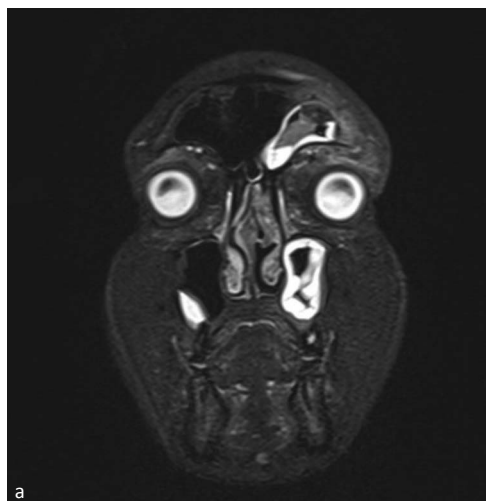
MRI with contrast: In comparison to the previous CT examination, there was smaller edema of the left maxillary mucosa, there was present residual abscess in the superior part of the left orbit 10 x 3 x 4 mm. The edema of the soft tissues around the abscess was found. There are signs of the edema and enhancement of the bone marrow of the left frontal bone, laterally to the frontal sinus – the suspicion of the bony inflammation. The enhancement of the dura above the frontal lobe was also found – with the dural thickening in this area at the length of 10 mm at the level of the inflammation in the frontal sinus. The most concerning finding was a linear loss of contrast in the posterior part of the superior sagittal sinus-condition after previous thrombosis? Thickening of the rest of the left sinuses like in the previous CT
